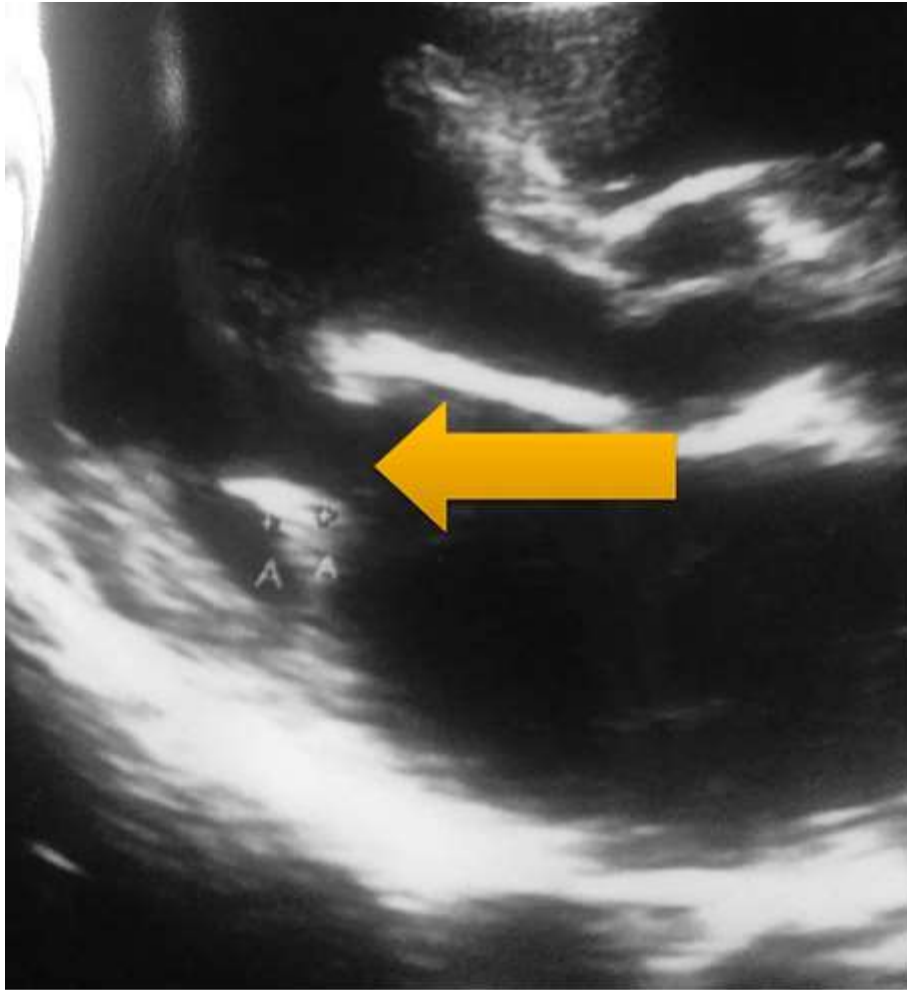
Echocardiography showing vegetation at mitral valve
